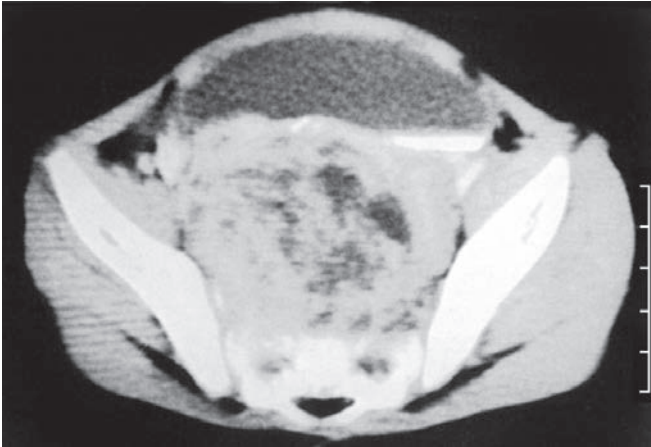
CT scan showing mixed density pelvic recurrence of a malignant yolk sac tumour in a patient aged 16 months
